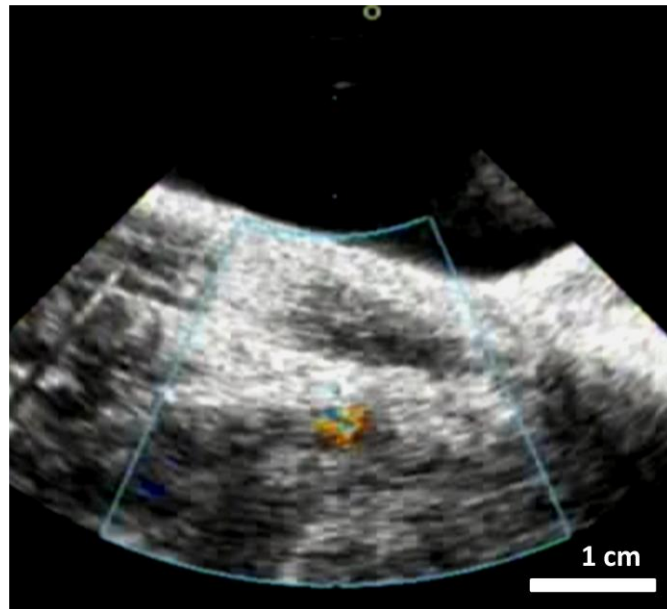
Color Doppler ultrasound image during application of therapy at low PRF, with a bubble cloud formed in an occluded femoral vein lumen. A strong Doppler signal is present in the lumen when a bubble cloud is generated, which may provide a more sensitive method of bubble cloud detection.
